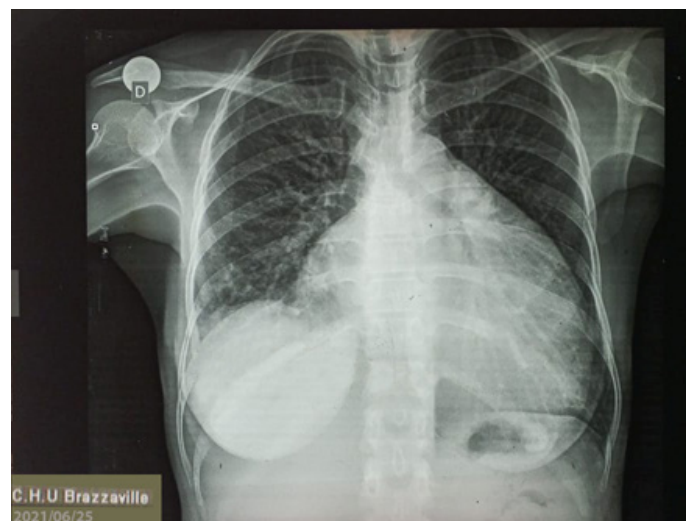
Anteroposterior chest X-ray showing cardiomegaly (cardiothoracic index = 0.67) and a mitral-type cardiac silhouette.
